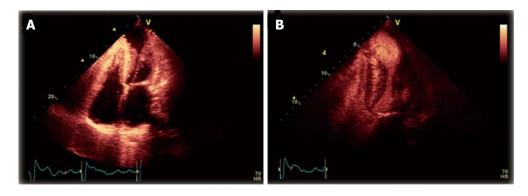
Transthoracic echocardiogram. A: Transthoracic echocardiogram (TTE), apical four-chamber view, demonstrating concentric left ventricular hypertrophy with mid-cavitary obliteration at end-systole, as well as a large left-ventricular apical aneurysm (LVAA); B: TTE apical two-chamber view, with ultrasound contrast demonstrating stasis within the LVAA with a circular flow pattern, as well as decreased perfusion of the apex.
